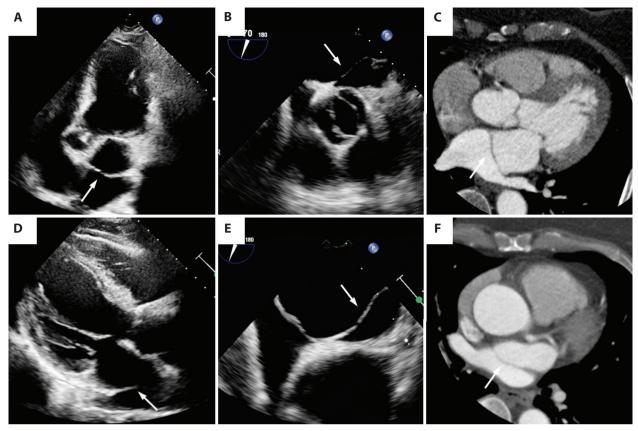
A. Transthoracic echocardiography — apical view. B. Transesophageal echocardiography — the bicuspid valve and left atrium membrane. C. Computed tomography angiography. D. Transthoracic echocardiography — long axis view. E. Transesophageal echocardiography — the left atrium membrane. F. Computed tomography angiography. The white arrow in all panels indicates the left atrium membrane
